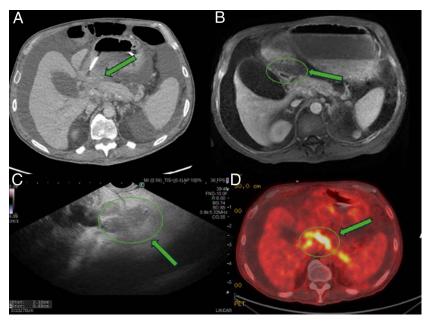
Cross-sectional imaging reveals an ill-defined soft tissue density (green arrow) around the porta hepatis on both (A) computed tomography and (B) magnetic resonance cholangiopancreatography. Nasogastric tube in situ for decompression of gastric outlet obstruction. Background large volume ascites is noted. (C) Endoscopic ultrasound reveals an ill-defined soft tissue mass with associated lymphadenopathy. (D) PET-computed tomography demonstrates overlapping fluorodeoxyglucose avidity. PET, positron emission tomography.
